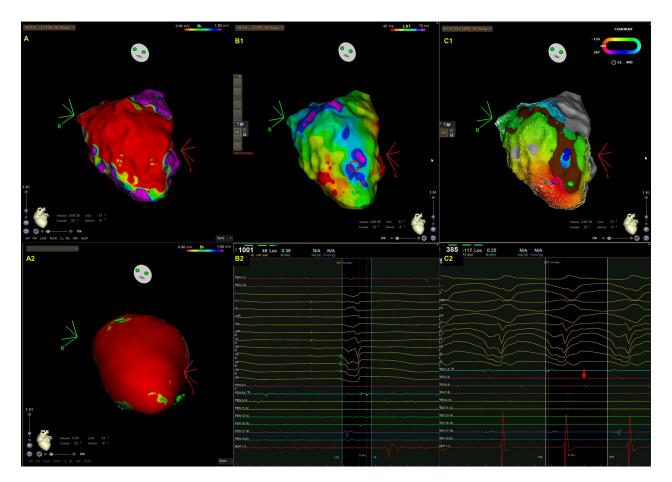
A representative case of intramural ventricular tachycardia (VT) in a patient with arrhythmogenic left ventricular cardiomyopathy (ALVC) caused by titin mutation. Endocardial bipolar voltage (A) and preprocedural cardiac MRI (A2) revealed extensive scarring along the anterior septum and anterior wall, extending from the base of the LV to its apex. The scars identified by cardiac MRI are larger than those detected by endocardial bipolar voltage mapping owing to the presence of intramural scarring. (B1–2) An isochronal late activation map (B1) created by annotating the latest component of bipolar electrogram during right ventricular pacing and fractionated potential (B2) recorded within scar (red circle in B1). In particular, an isochronal crowding region was noted close to the scar border in the LV apex. (C1–2) VT activation map (C1), VT morphology and diastolic potential (C2). VT cycle length was 385 milliseconds with a left bundle branch block morphology and superior axis. The VT activation map (from red, orange, yellow, green, blue, indigo, to violet) demonstrated an incomplete circuit characterized by an activation gap (parts of the blue and violet are missing) within the endocardium. The mid-diastolic potential (red arrow, C2) was recorded at the blue dot site (C1). After radiofrequency energy was applied to the blue dot area, VT was terminated.
